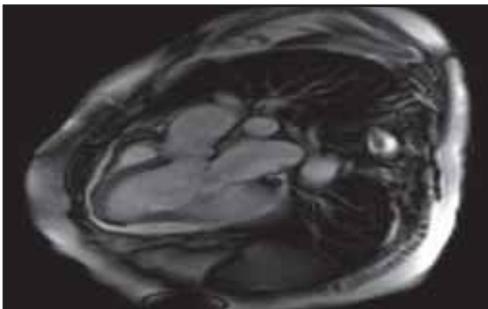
MRI showing large pseudo-aneurysm
